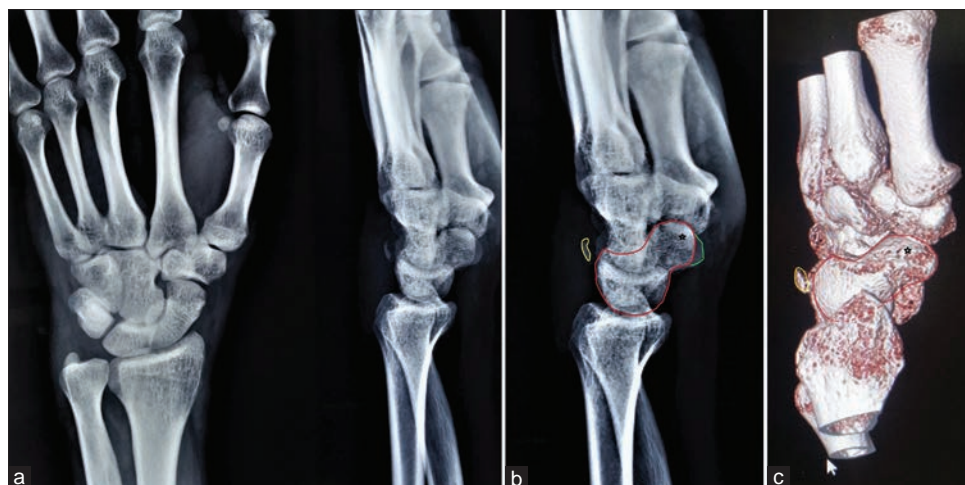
The radiograph of the wrist in orthogonal planes, showing no major fracture except cortical fleck of a bone lying dorsal to the carpal bones in lateral view (a). The impressions on the lateral radiograph (b) with colored lines showing the scaphoid and lunate superimposing on the triquetrum and thus making the body of the “duck” (red line) and the avulsed fragment posterior to it resembles the “poop” (yellow). The CT lateral images corresponding to similar impression as noted in the lateral radiograph (c). CT: Computerized tomography
